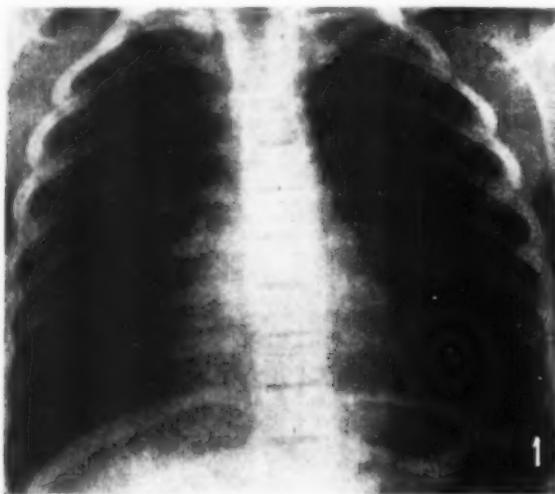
(Case 15): A normal X-ray in a typical ductus, aged 6 years.
